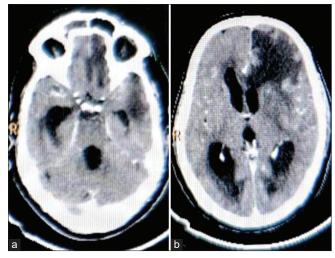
(a and b) Contrast-enhanced computed tomography (CECT) scans of the brain demonstrate left frontal and temporal early cerebritis with hydrocephalus in a case of rhino-orbitocerebral mucormycosis (ROCM) with fungal meningitis.
